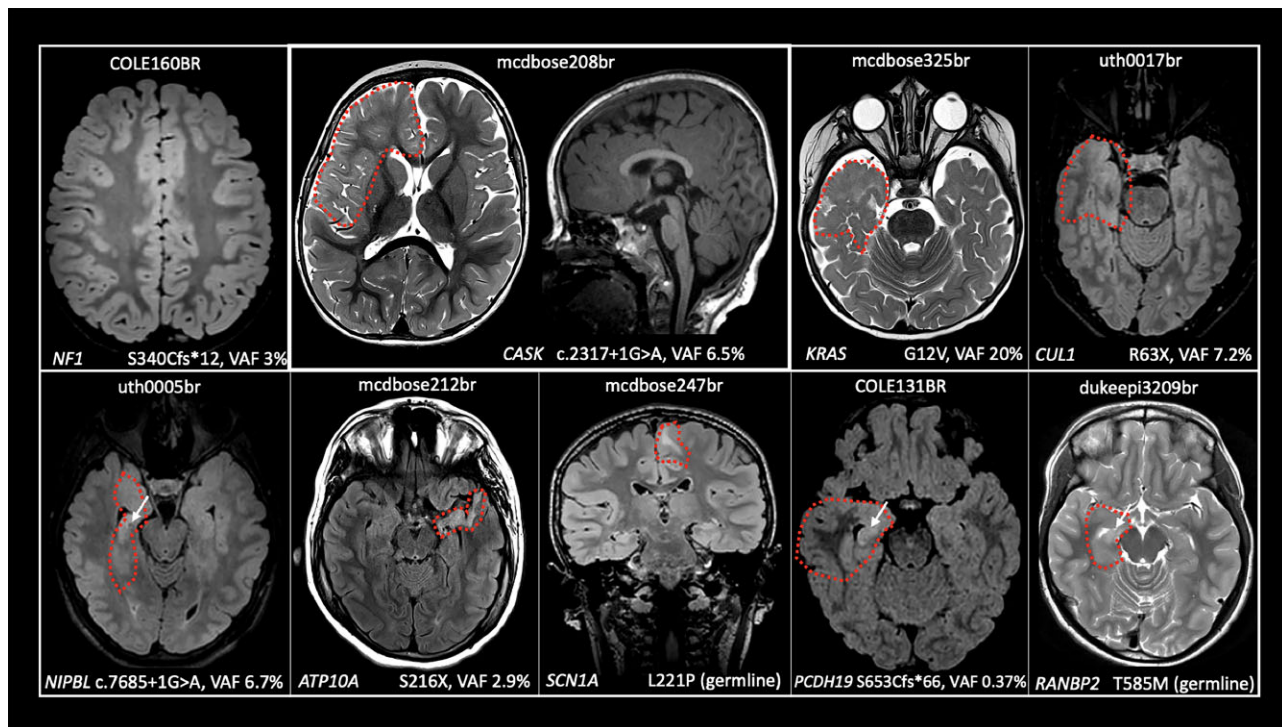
Brain MRIs for subjects with novel somatic variants. Each subject is shown using a mixture of axial T₂- and FLAIR-weighted imaging sequences with the exception of mcdbose208br, for which a sagittal T₁ is also provided, and mcdbose247, which is depicted in the coronal plane (annotations as in Fig. 2). The cortical malformation is outlined by a dashed line except for COLE160BR, which was a non-lesional case. Lesions were classified as FCDIIB for mcdbose247br and FCDIII in three cases (uth0005br, COLE131BR and dukeepi3209br with hippocampal sclerosis indicated by the arrow). The remaining cases were classified as FCDI+ (COLE160BR, mcdbose208br, mcdbose325br, uth0017br, mcdbose212br). Note that mcdbose208br demonstrates normal hindbrain volume, unlike germline variants in CASK. VAFs obtained from exome sequence data are provided for each somatic variant in the bottom right.
